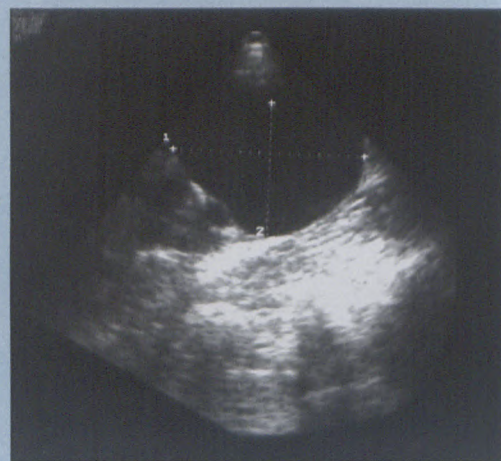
Ultrasound of the lower pole of the right kidney demonstrating a 7.3 cm by 5.6 cm hypoechoic lesion
